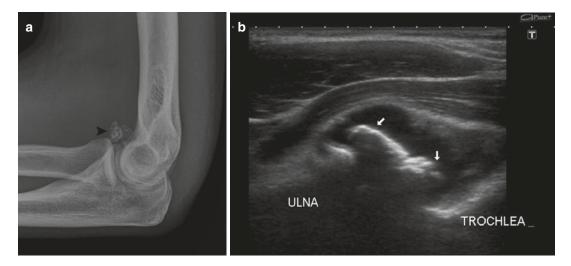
(a, b) Synovial chondromatosis of the elbow in a 21-year-old male: (a) plain radiograph (lateral view) showing two ossified nodules at the ventral aspect of the elbow joint (*arrowheads*). (b) Longitudinal ultrasound shows joint effusion and intra-articular loose bodies with retro-acoustic shadowing (*arrows*)
